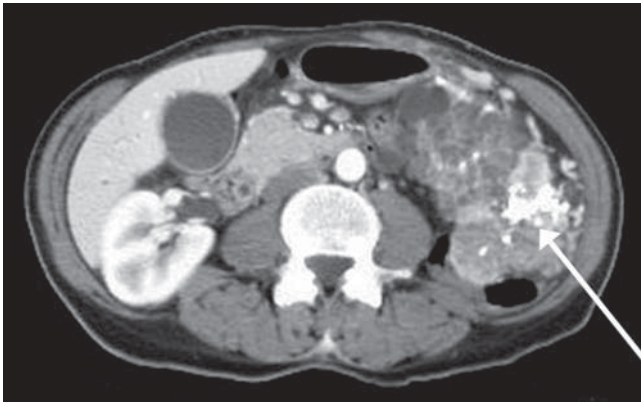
Contrast-enhanced abdominal computed tomography (CT), showing a huge multilocular cystic mass of the pancreas. Honeycomb appearance and calcifications within a central fibrous scar (*arrow*) are visible. The thin cystic walls are enhanced by the intravenous contrast
